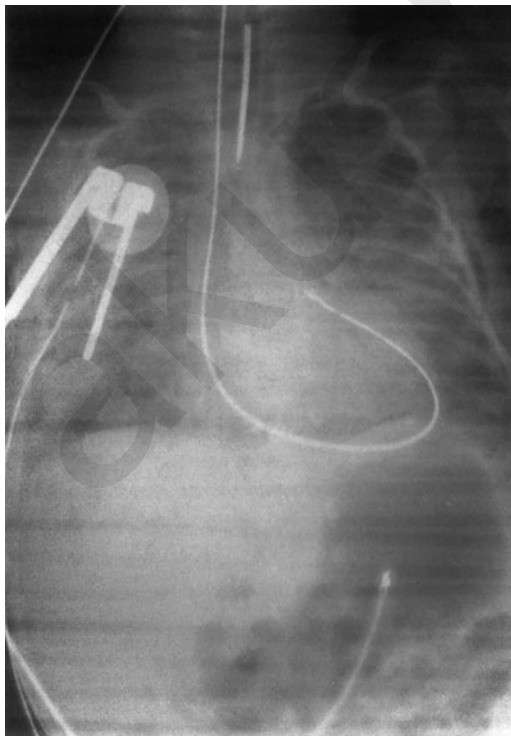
Chest x-ray shows displacement of the nasogastric tube to the pericardial sac.
